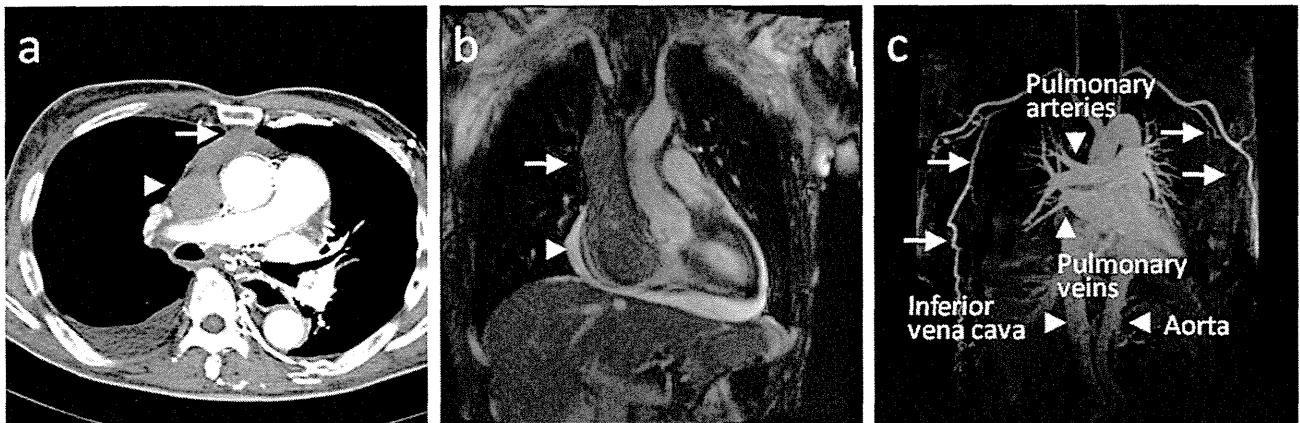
Imaging studies. (a) Chest computerized tomography showing an anterior mediastinal tumor (arrow) that consecutively extends into the left brachiocephalic vein and superior vena cava (arrowhead). (b) Coronal view of a chest magnetic resonance imaging scan showing a mediastinal mass within the superior vena cava (arrow) that consecutively extends into the right atrium (arrowhead). (c) Angiography of large vessels including the pulmonary arteries and veins, aorta, and inferior vena cava. The superior vena cava is not observed. Instead, meandering dilated thoracoepigastric veins are delineated (arrows).
